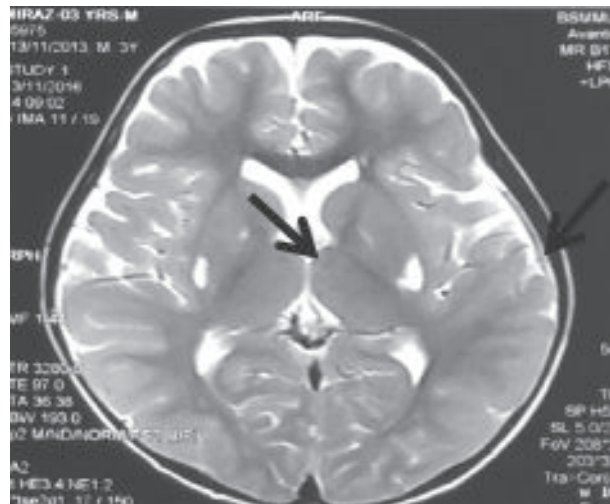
MRI of brain T2 image showing bilateral symmetrical lesions in the basal ganglia
